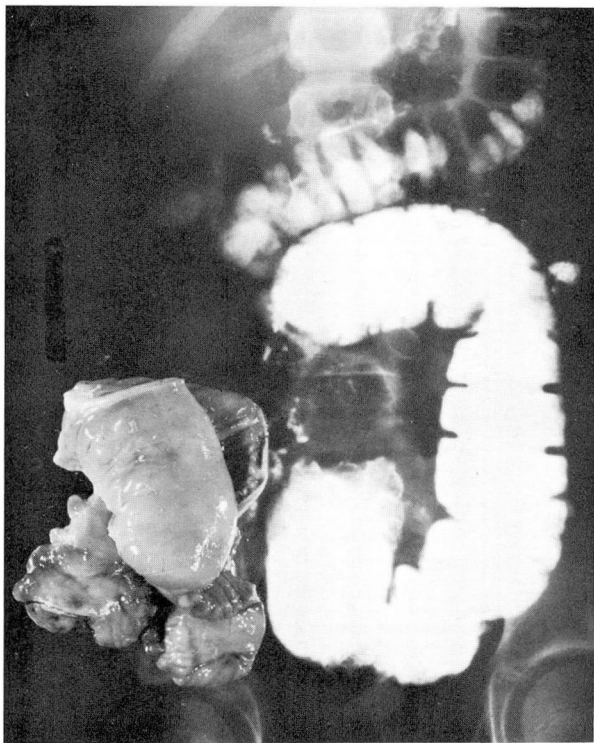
Montage demonstrating the roentgenogram of the small bowel and the resected tumor in its relative position.
